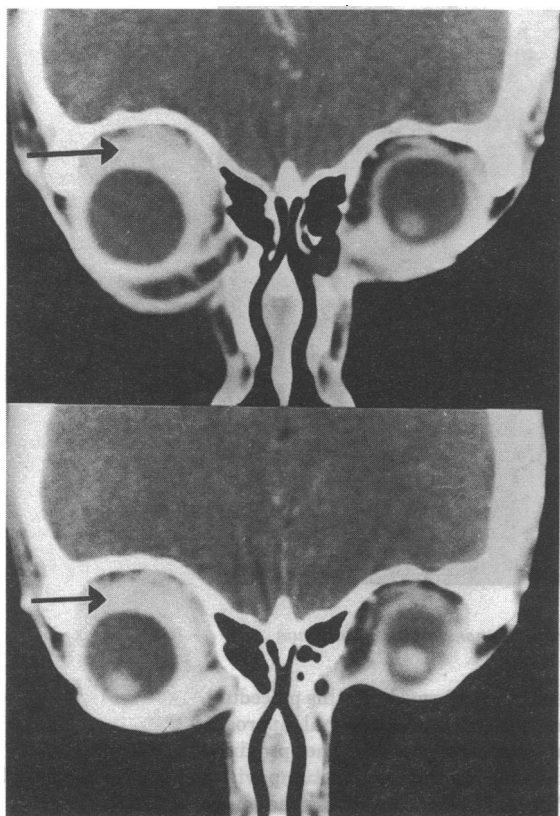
CT scan of head (coronal section) showing extensive soft tissue infiltrate around the right globe (arrow)
